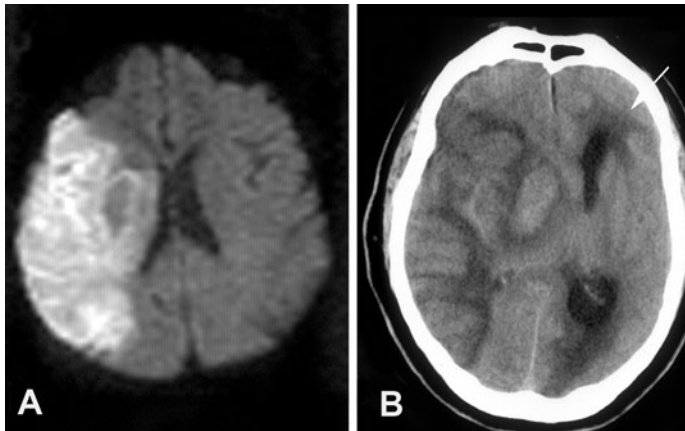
(a) Diffusion-weighted MRI of a patient with large middle cerebral artery stroke. There is involvement of the entire vessel territory with possibly some hemorrhage in the basal ganglia. The image was made within hours of the infarct and there is minimal compression of the ventricles. (b) CT days after the infarct shows the massive shift of the midline structures away from the evolving mass lesion. Compression of the CSF outflow tracts causes the hydrocephalus with interstitial edema in the white matter adjacent to the ventricles
